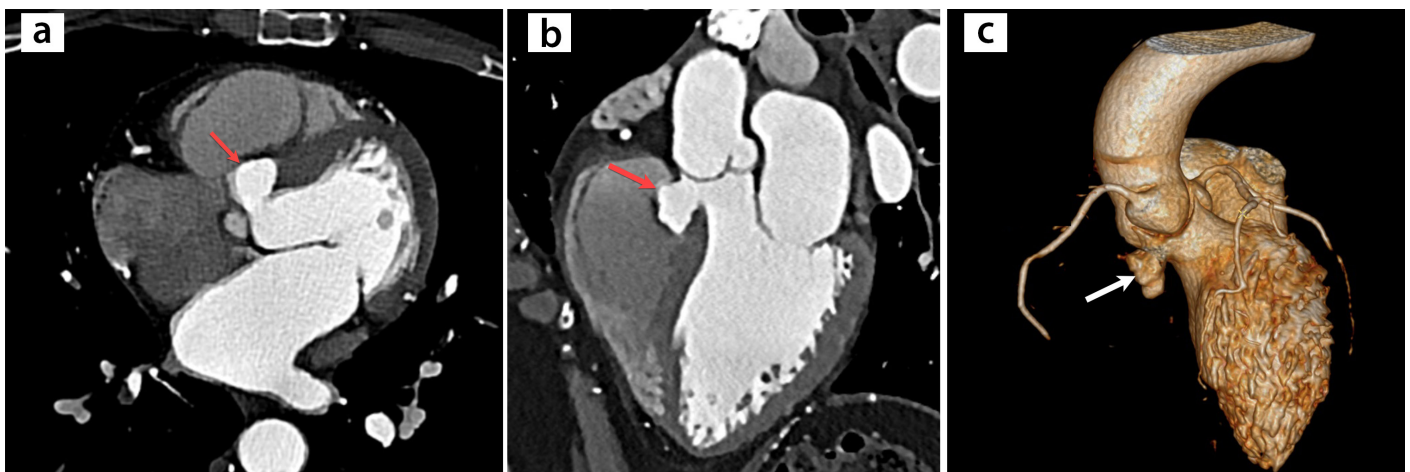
(a-c) A 45-year-old female patient with an abnormal finding on echocardiography underwent contrast-enhanced cardiac computed tomography (CT) angiography. (a) Axial, (b) multiplanar reformatted, and (c) three-dimensional volume rendering CT images demonstrating the bowing of the interventricular septum to the right (arrows), consistent with membranous interventricular septal aneurysm. The patient refused surgery and was followed up with anticoagulation.
